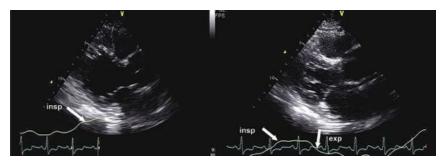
CP: 2D parasternal long-axis view demonstrating proper use of a respirometer in a patient with CP. A high-quality tracing demonstrating both inspiration and expiration is essential. The *left panel* and *arrow* point to upslope in inspiration only (Video A7). The *right panel* and *arrows* point to the peak of inspiration and expiration after an adjustment of the respirometer was made (Video A8).
